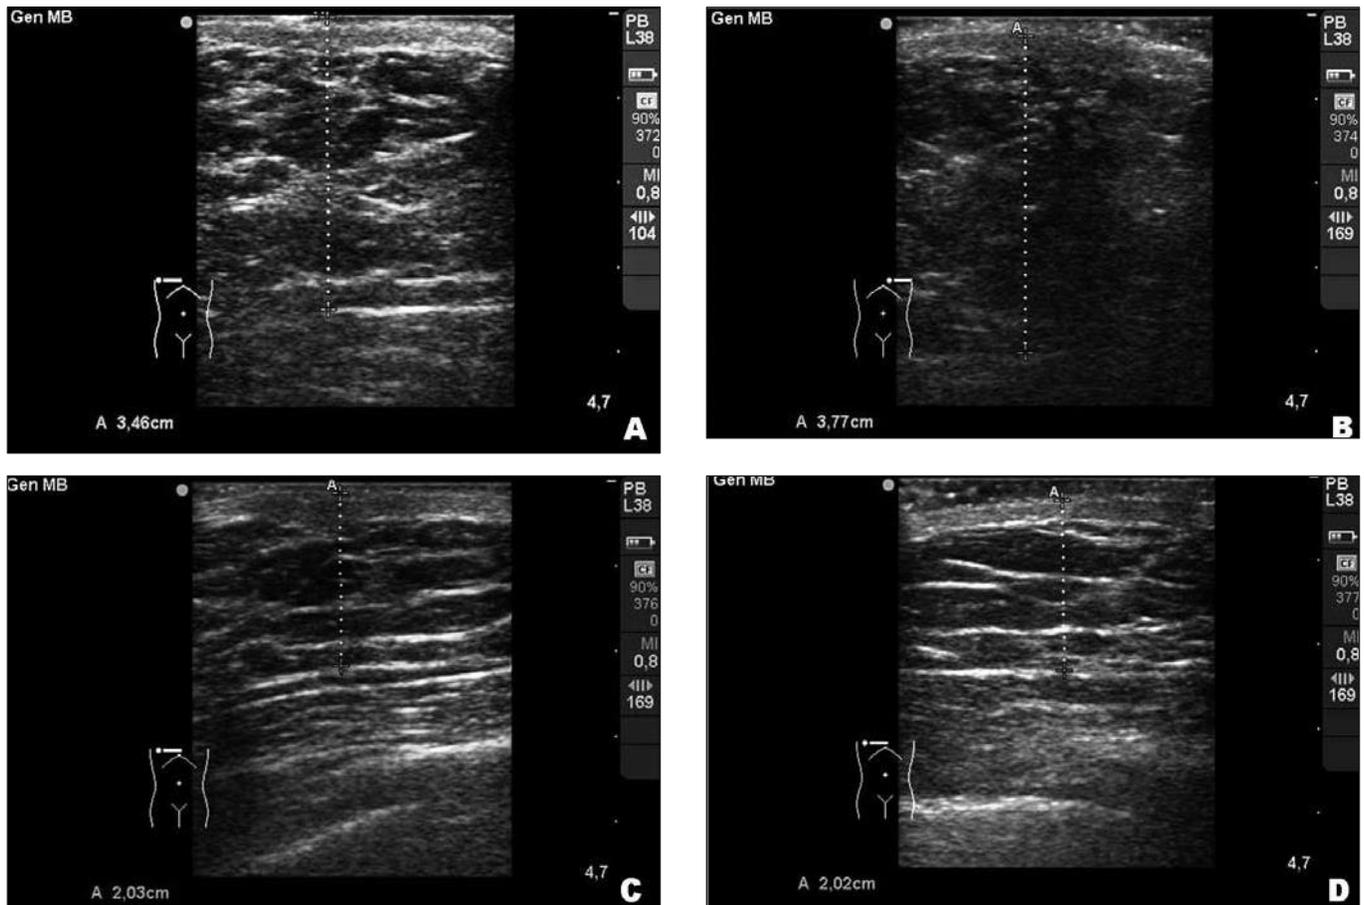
Ultrasonography of the patient of Figure 6. A. Right breast before laser lipolysis; B. Left breast before laser lipolysis; C. Right breast 6 months after the surgery; D. Left breast 6 months after surgery. The ultrasonography performed 6 months after the surgery shows an increase in the thickness of the dermis and a decrease in the subcutaneous fat. We also observed an evident alignment of the fibrous septa in a parallel position with relation to the cutaneous surface.
